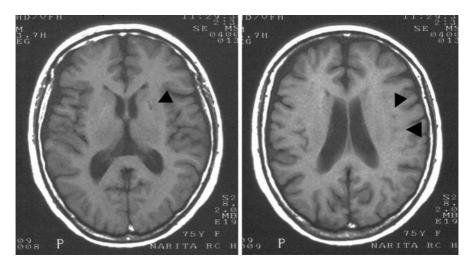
Magnetic resonance imaging (MRI) findings (T1 image, 9th day). Arrowheads, low density area suggesting infarction
